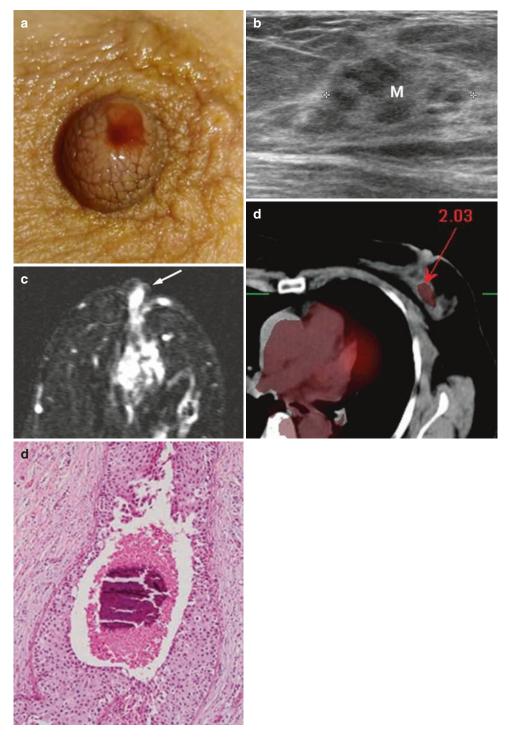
Ductal carcinoma in situ in a 51-year-old woman. (a) Bloody nipple discharge. (b) Sonogram showing a lobulated hypoechoic lesion (M), a finding suggestive of malignancy. (c) Axial contrast-enhanced substraction MRI showing a nodular clumped linearly enhanced lesion with direct invasion of the nipple (*arrow*). (d) Positron
